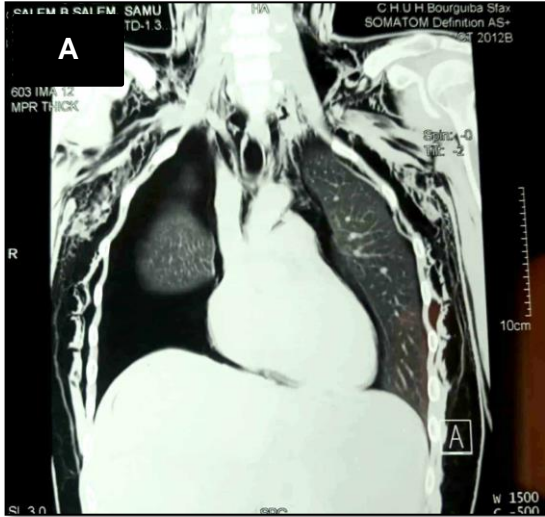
The CT scan showing an anterior pneumothorax on the right side (A) with a collapsed lung and a deviation of the mediastinum to the left side (B)
